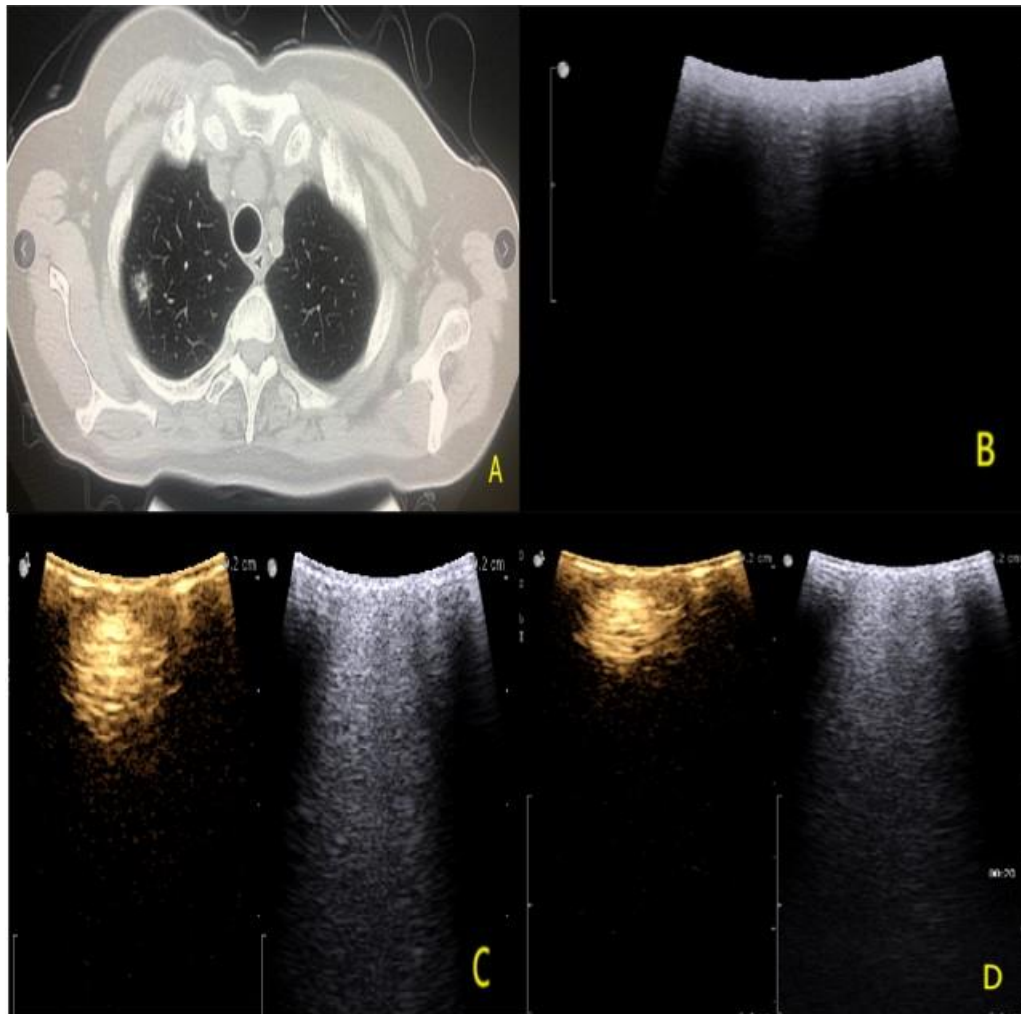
Preoperative HRCT, intraoperative ultrasonic and contrast-enhanced ultrasonic images of mGGN. A. Before operation, HRCT showed mGGN nodules about 13mm in diameter in the apical segment of the upper lobe of the right lung, with uneven density, irregular shape, spiny changes, lobulation sign and pleural indentation sign. B. The intraoperative two-dimensional ultrasonic showed that the echo in the nodule was uniform, hyperechoic, the boundary was not clear and the shape was regular. C, D. Intraoperative CEUS showed that the nodules began to enhance in 9 seconds, reached
